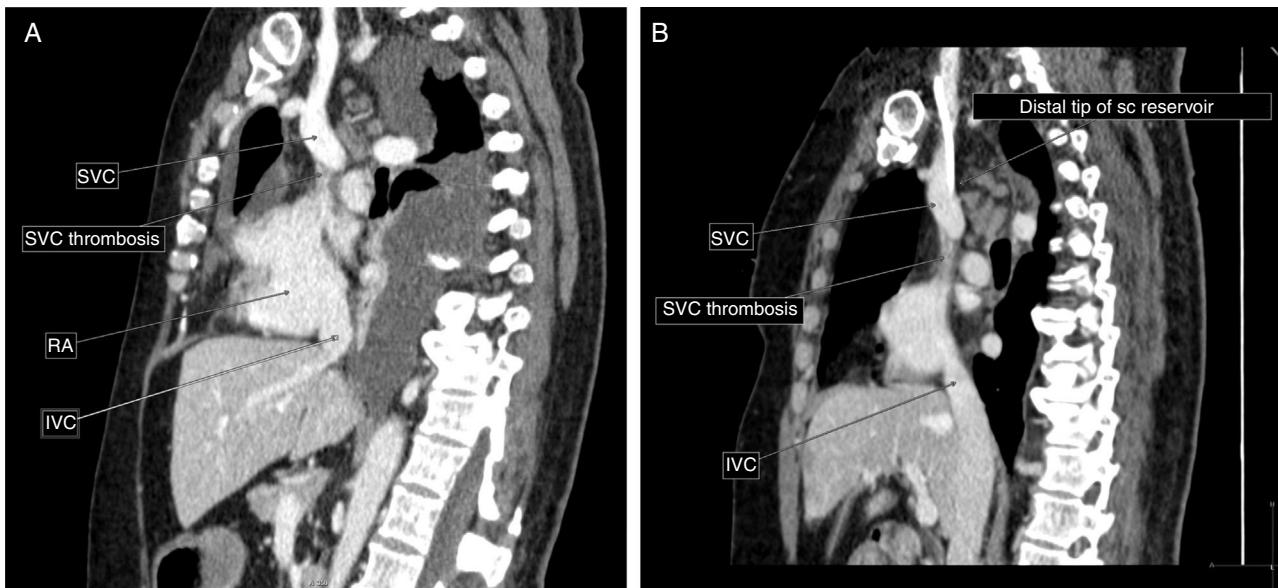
(A) Computed tomography with intravenous contrast in the venous phase. Sagittal slice. A superior vena cava filling defect is visualized proximal to the mouth of the arch of the azygous vein, extending to the entry into right atrium, consistent with at least partial thrombosis of the structure, and associated with significant effusion. (B) Sagittal slice. Distal tip of the subcutaneous reservoir in relation to the subcutaneous vena cava thrombosis. IVC: inferior vena cava; RA: right atrium; sc: subcutaneous; SVC: superior vena cava.
